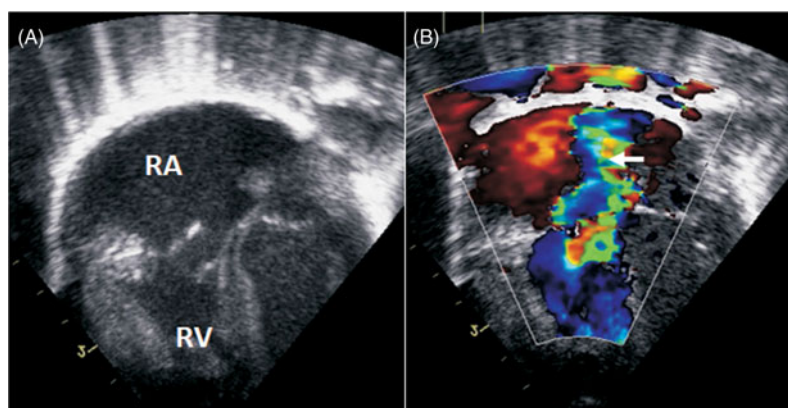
Typical postnatal echocardiographic appearance. Typical four-chamber echocardiogram of infant with post-natal presentation of ductal dysfunction in patient no 16. The patient presented with a dilated right atrium and ventricle, pulmonary hypertension and cyanosis. (A) The patient has severe RV hypertrophy (210% LV free wall) with a flail valve due to ruptured chordae (arrow). (B) Severe tricuspid regurgitant jet (blue) can be observed with colour Doppler mapping (arrow).
